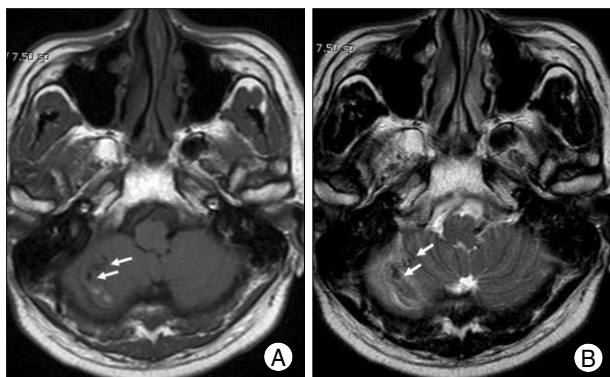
Axial T1-weighted (A) and T2-weighted (B) magnetic resonance image showing tangled signal voids (arrows) near the right cerebellar hematoma.
